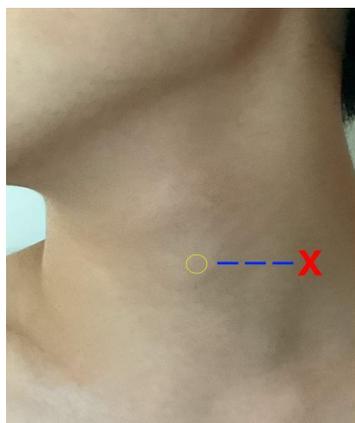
Landmarks of ultrasound probe placement and needle insertion (O: cricoid cartilage; ---: high frequency linear ultrasound probe; X: needle insertion point)
